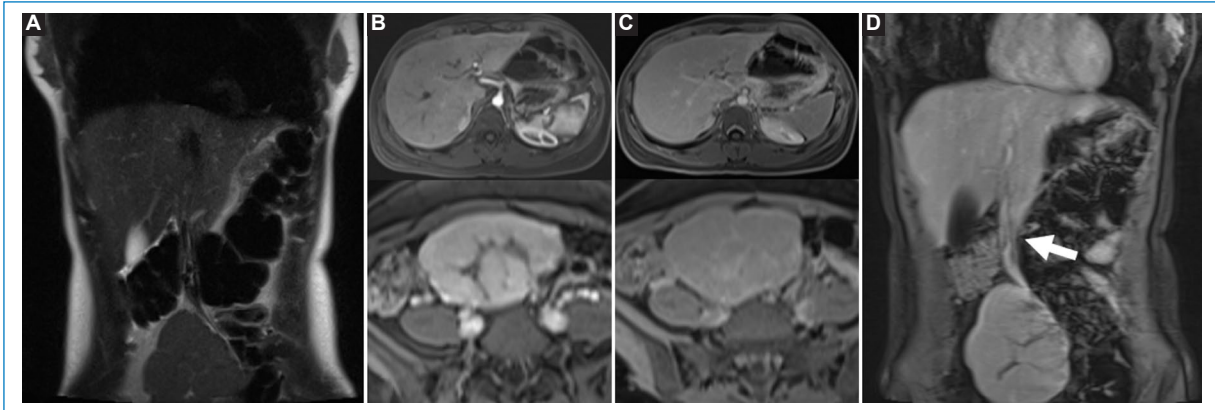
Abdominal magnetic resonance imaging with intravenous extracellular (gadolinium) contrast. The lesion is isointense to the liver on pre-contrast T1 and T2 sequences, with a center corresponding to the central scar, showing intermediate-to-high signal intensity on T2 sequences (A) and mildly hypointense on T1. In the dynamic post-contrast phases, it shows homogeneous avid enhancement in the arterial phase (B) and is isointense in the portal and delayed phases (D and C, respectively). The central scar is hypointense in the early phases with enhancement in the delayed post-contrast phase (D), where the vascular pedicle can be seen (arrow).
